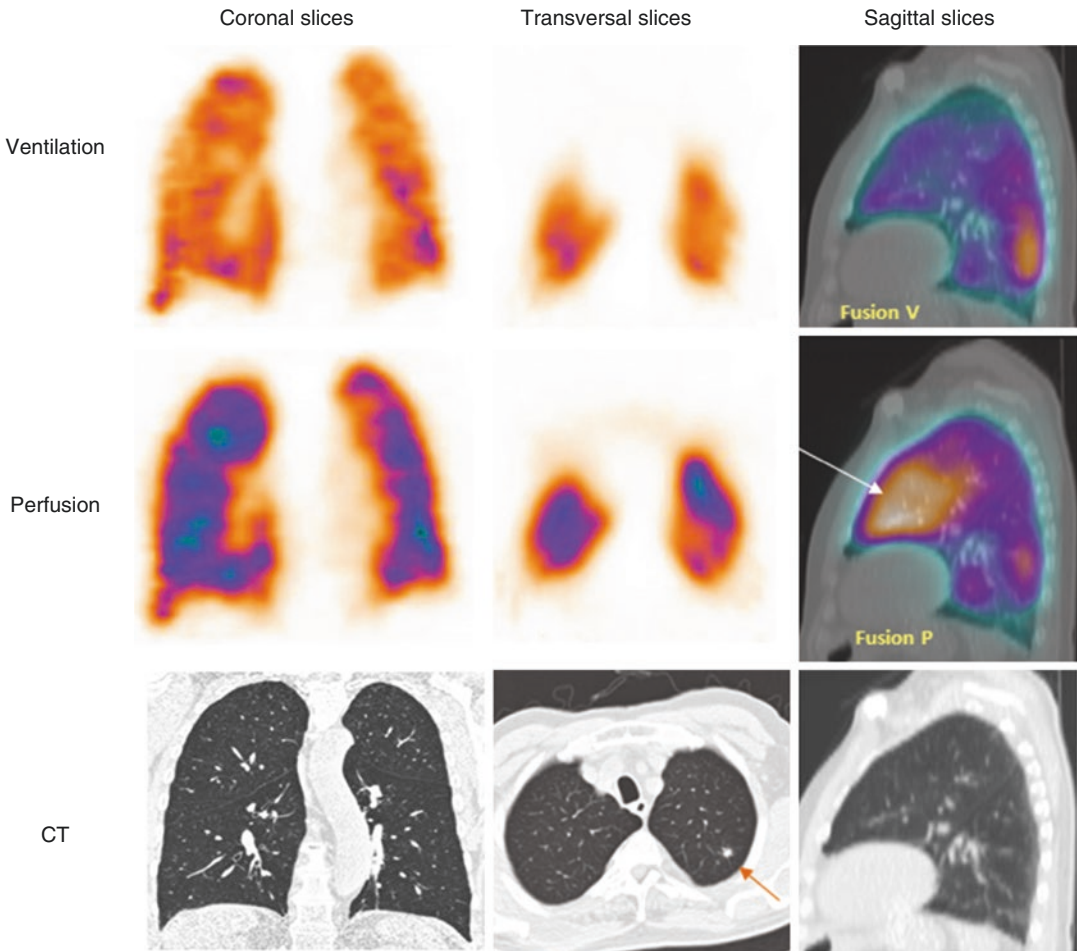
Patient with COPD, small tumour and left heart failure. Coronal and transversal slices of ventilation and perfusion SPECT image: On the right, corresponding sagittal V/P SPECT/CT fusion images. In the lower row, corresponding CT images. On CT image small tumour (1 cm)
